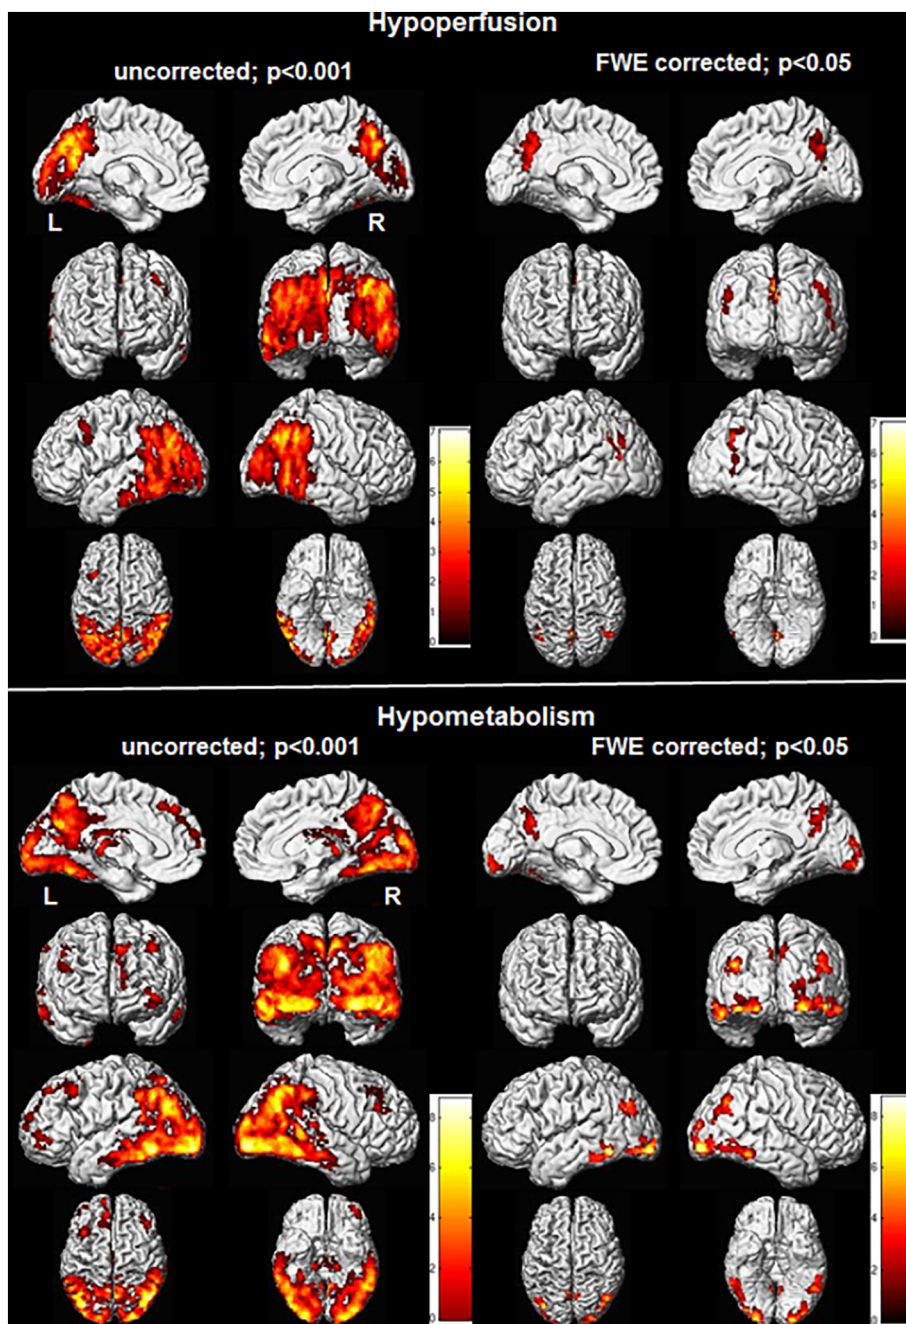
Cortical hypoperfusion on ASL-MRI and hypometabolism on FDG-PET in DLB patients.
